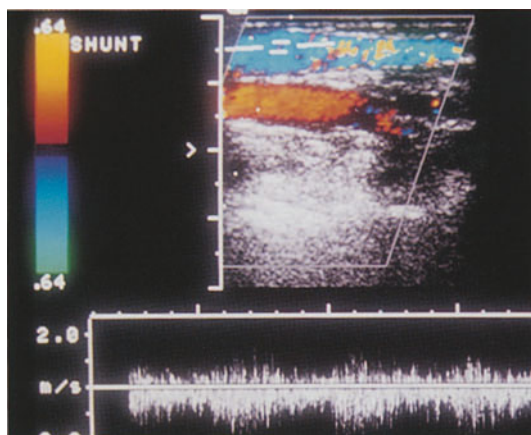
(left) Normal venous limb (proximal part) further from the anastomosis in a dialysis fistula: the systolic velocity peaks are less prominent than in the distal part reflecting increased distance from the feeding artery. The Doppler spectrum shows varying amplitudes
